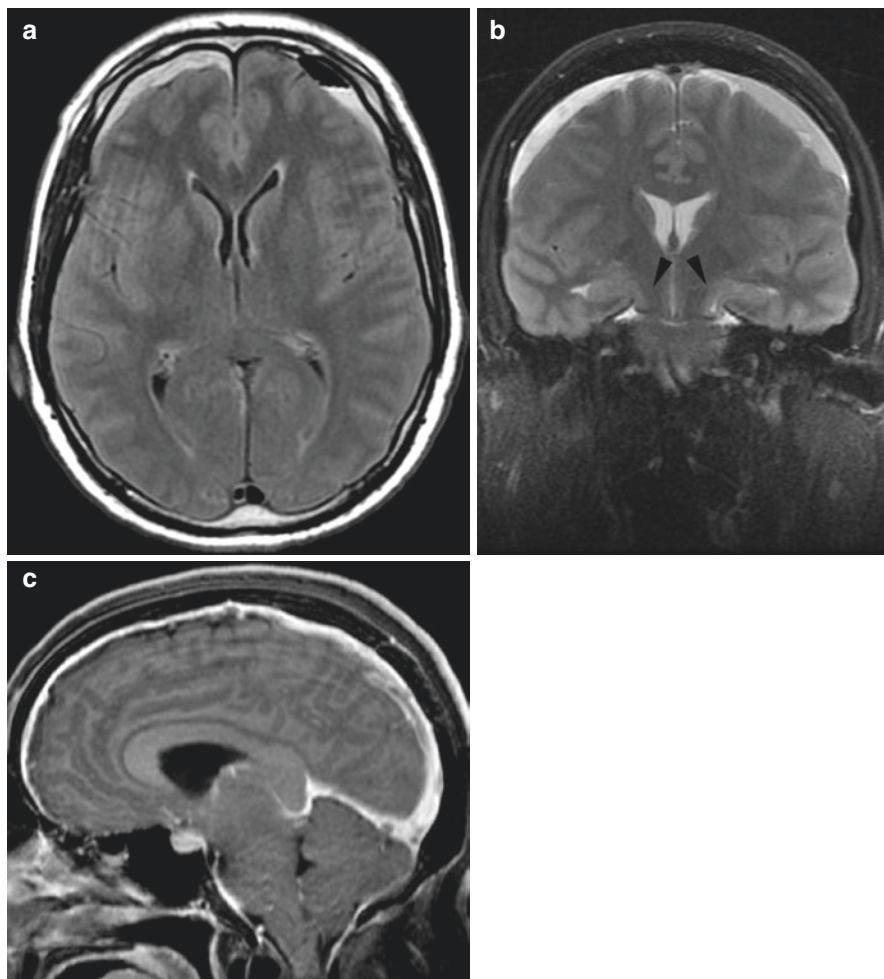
Signs of liquoric hypotension in MR imaging. Axial FLAIR image (a) shows hygromas in both frontal regions and small sized ventricles. Coronal T2 image (b) demonstrates the same fluid collection, but also signs of sagging brain with herniated uncus bilaterally. Sagittal post-contrast T1 image shows diffuse post-contrast pachymeningeal enhancement, as well as pituitary turgescence and liquor paucity in the basal cisterns with signs of sag of the brainstem
